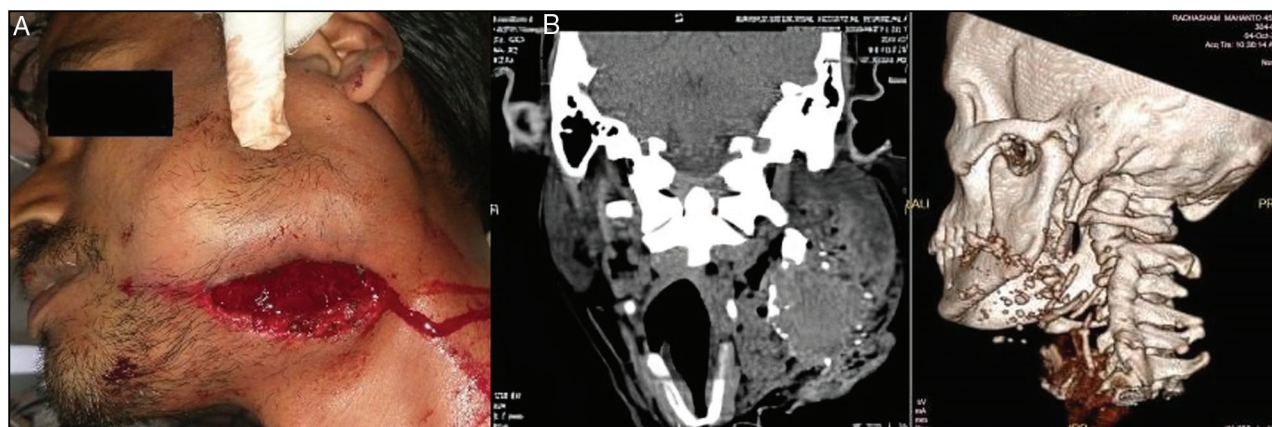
(A) Pre-operative picture of the patient. (B) Pre-operative CT scan
